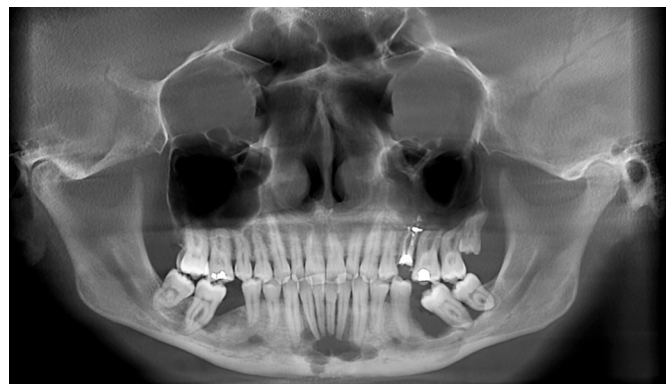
Panoramic radiograph showing important alveolar bone loss, in particular around left mandibular molars, and multilobular radiolucent image in the periapical area of the mandibular incisors.
